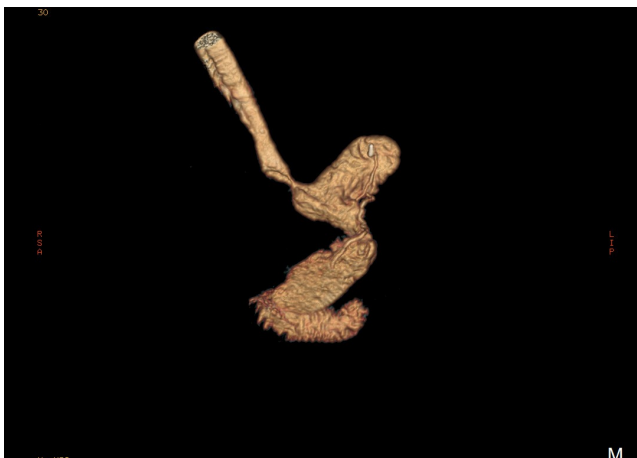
CT volumetry showed missed funds post LSG.
